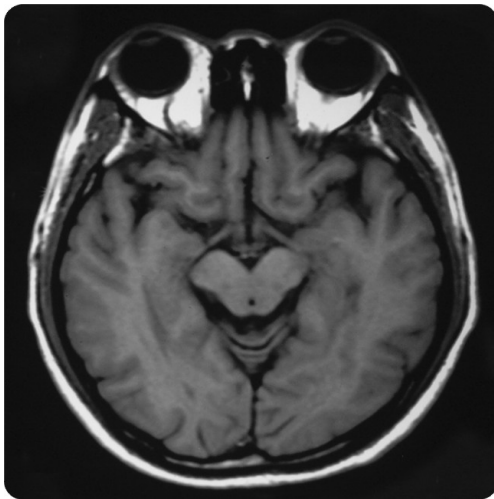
Magnetic resonance imaging shows the prominent right ophthalmic vein.
